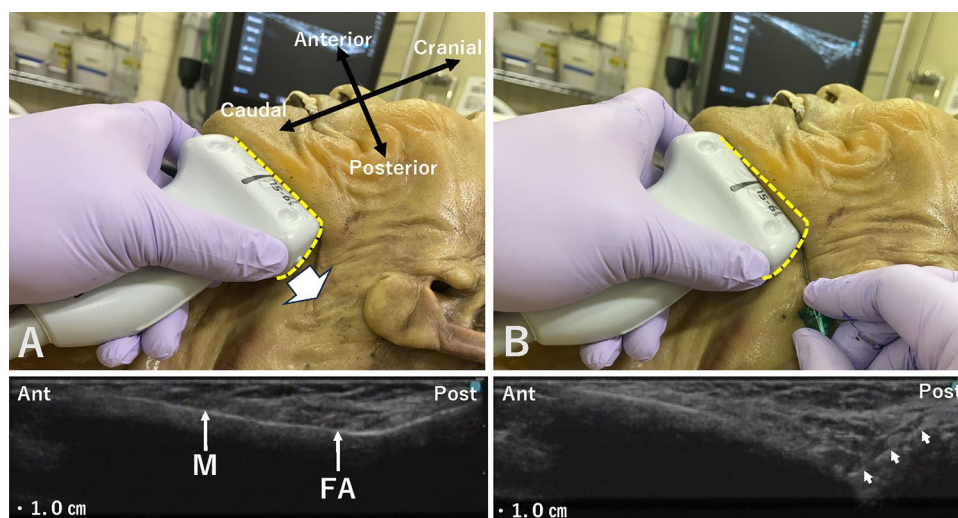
Technique of the IANB-MA. A The ultrasound probe is placed at the lower edge of the mandibular angle of the cadaver. The yellow line indicates the probe's position in contact with the mandible. B The proximal end of the probe is rotated inward and tilted outward to observe the medial aspect of the mandible (the yellow dashed line indicates the position of the probe contacting the mandible in A). The
